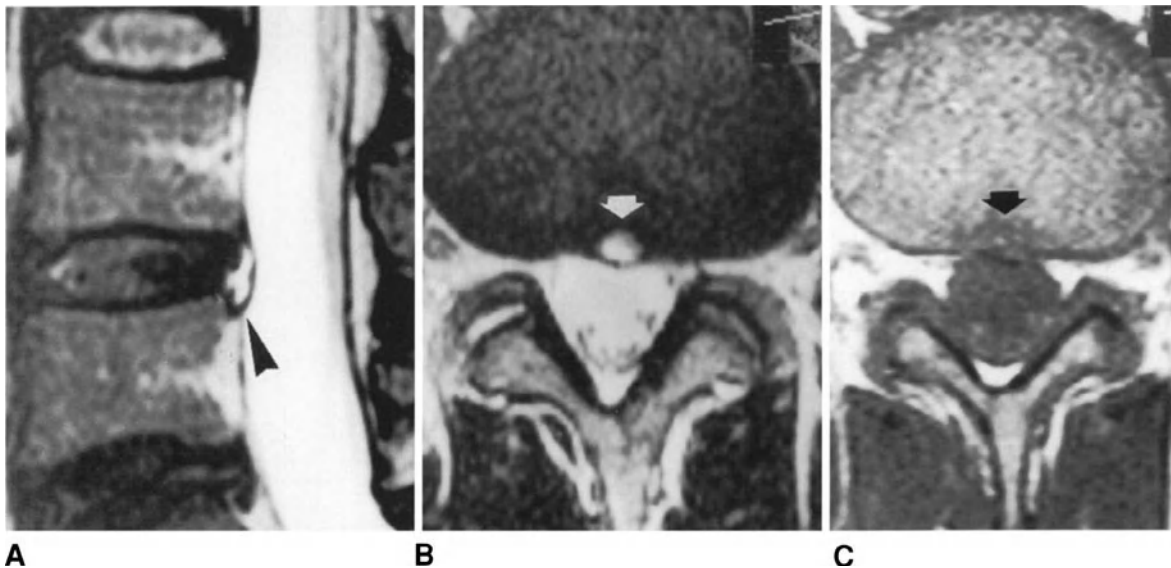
(A) Spin-echo T2-weighted MR image. A large hyperintense area (arrowhead) is visible in the posterior portion of the annulus fibrosus of the L4-L5 disc, which shows a decreased signal intensity. (B) Turbo spin-echo T2-weighted MR image. The area of high signal intensity in the annulus fibrosus is roundish on axial section (arrow). (C) Spin-echo T1-weighted MR image. The posterior portion of the L4-L5 annulus fibrosus shows a zone of decreased signal intensity with punctiform hyperintense areas (arrow).
